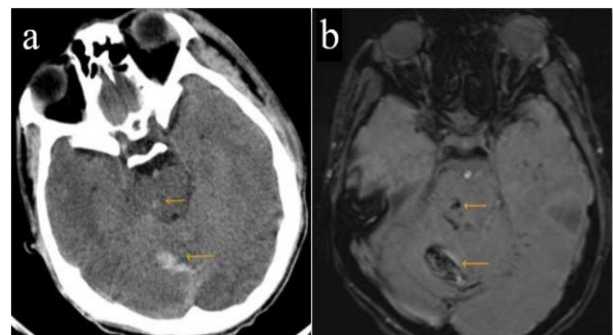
Computerized tomography (CT) scan (a) and magnetic resonance imaging (MRI) - susceptibility-weighted imaging (SWI) sequence (b) showing hemorrhages (yellow arrows) in right paramedian brainstem and cerebellum indicating grade 3 diffuse axonal injury (DAI).
